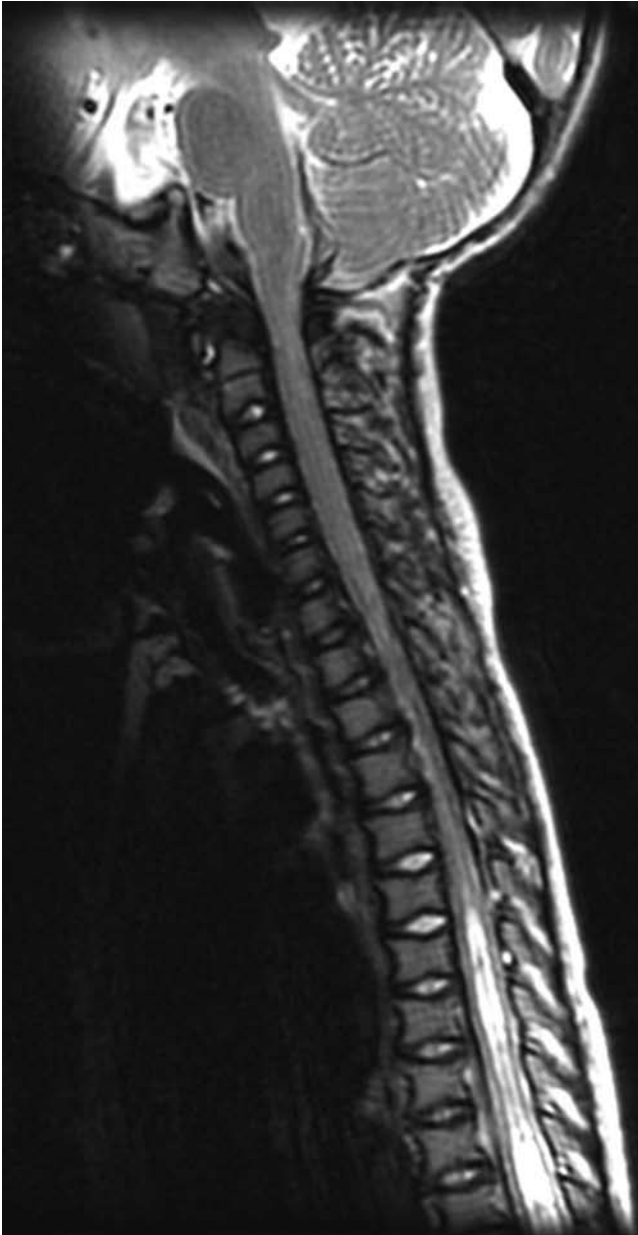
Sagittal T2-weighted MR image obtained in a 9-year-old boy with cervicomedullary compression, cervical and thoracic canal stenosis, and a thoracic syrinx.
